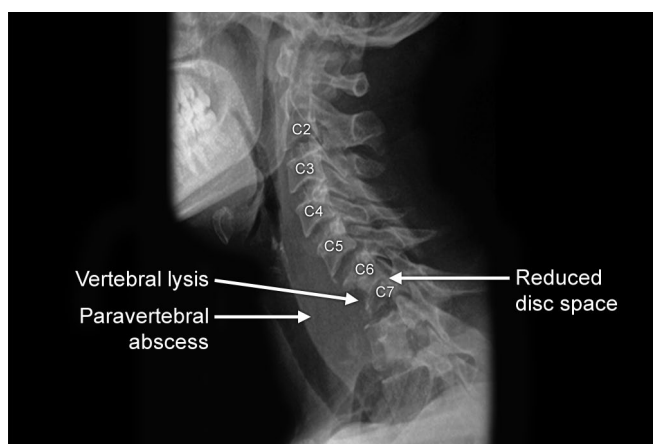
X-ray of cervical spine lateral view showing the classic triad of tuberculosis.
